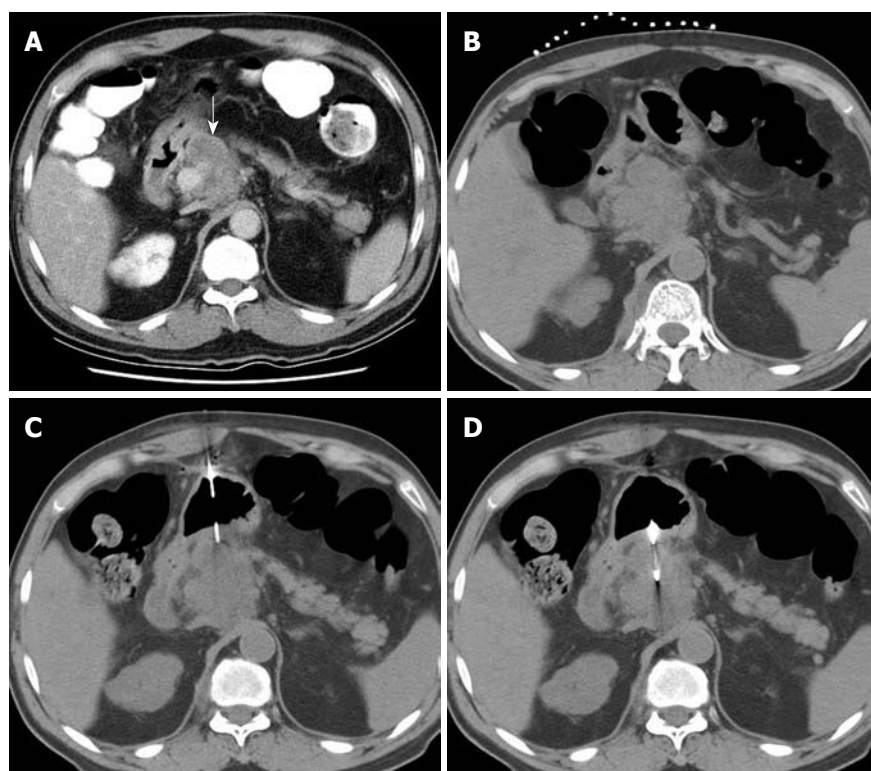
A 67-year-old man with a pancreatic mass who had no safe route for approaching the target lesion during biopsy. A: Contrast-enhanced axial computed tomography (CT) scan shows a mass lesion (white arrow) in the pancreatic head; B: The patient was in the supine position, with opaque catheters placed on the abdominal wall as reference lines; C: Noncontrast CT image shows a 17-gauge coaxial introducer needle perpendicularly penetrating the gastric wall and the needle tip positioned at the edge of the target lesion; D: Noncontrast CT image shows an 18-gauge biopsy needle tip in the pancreatic mass.
